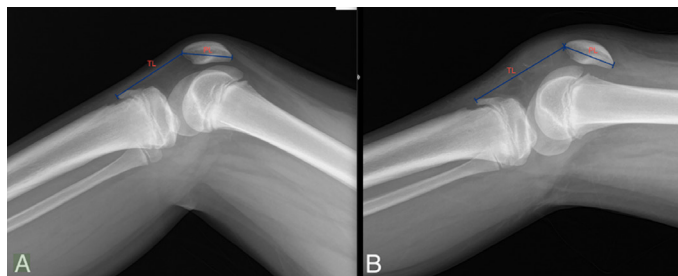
Preoperative x-ray of the (A) healthy knee; (B) affected knee showing considerable increase in tendon length (TL) and increased Insall-Salvati ratio of 1.89 (tendon length divided by the patellar length (PL) for the affected knee)
